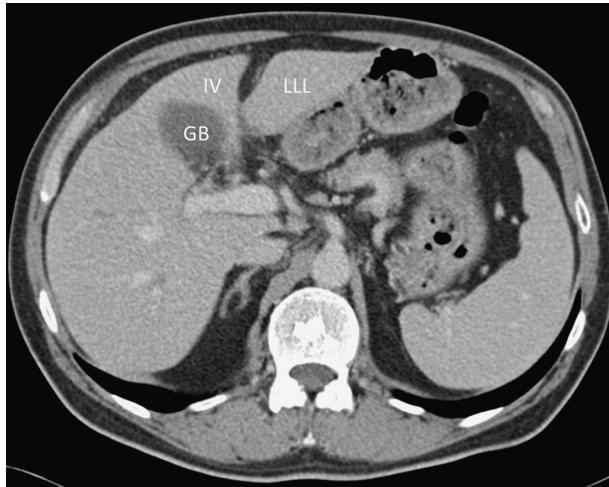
Axial portal venous phase CT in a 65-year-old man, with hepatocellular carcinoma developed on alcoholic cirrhosis obtained 22 days before the portal vein embolization. IV, I and LLL correspond to segment IV, I and the left liver lobe respectively, GB corresponds to the gallbladder.
